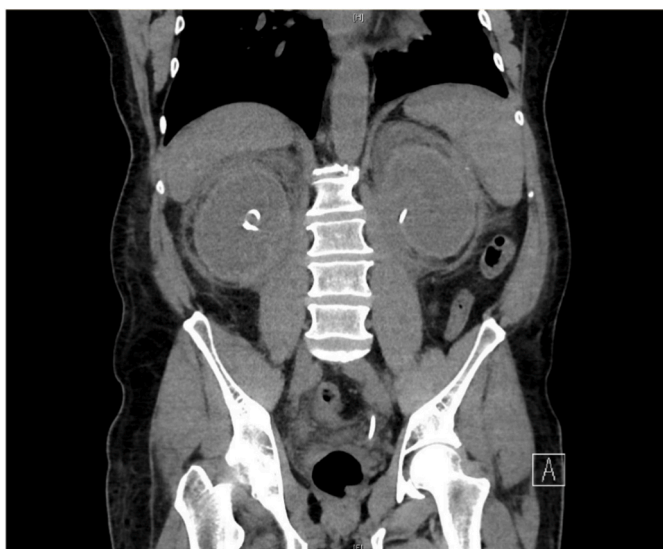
CT KUB December 2021. Bilateral rind like perinephric structure, ‘hairy kidney’. Ureteric stents insitu bilaterally.
